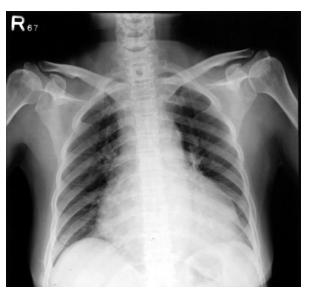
Chest X-ray on day 44 showing mild cardiomegaly, but no pleural effusion.
